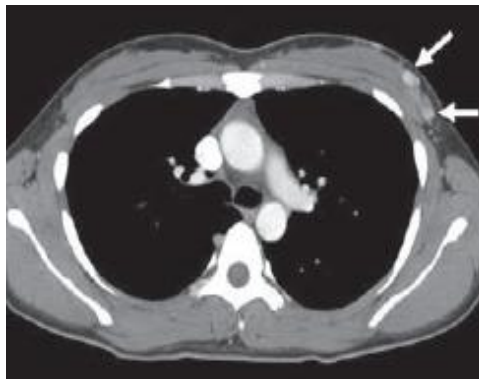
Contrast-enhanced CT image of chest shows nodular areas (arrows) of rapid contrast enhancement in left breast, corresponding to ACC.
